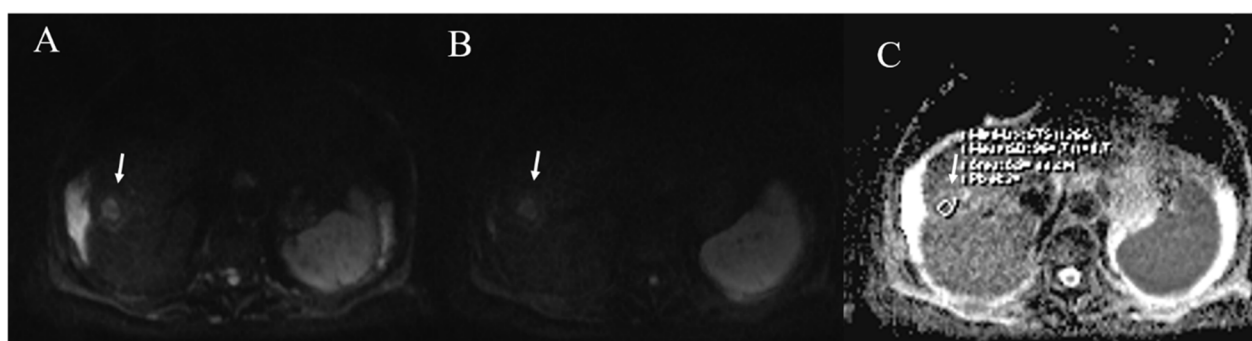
The same patient of Fig. 9. DWI assessment. The ablated area shows targetoid appearance in b50 s/mm², in b800 s/mm² and ADC map
